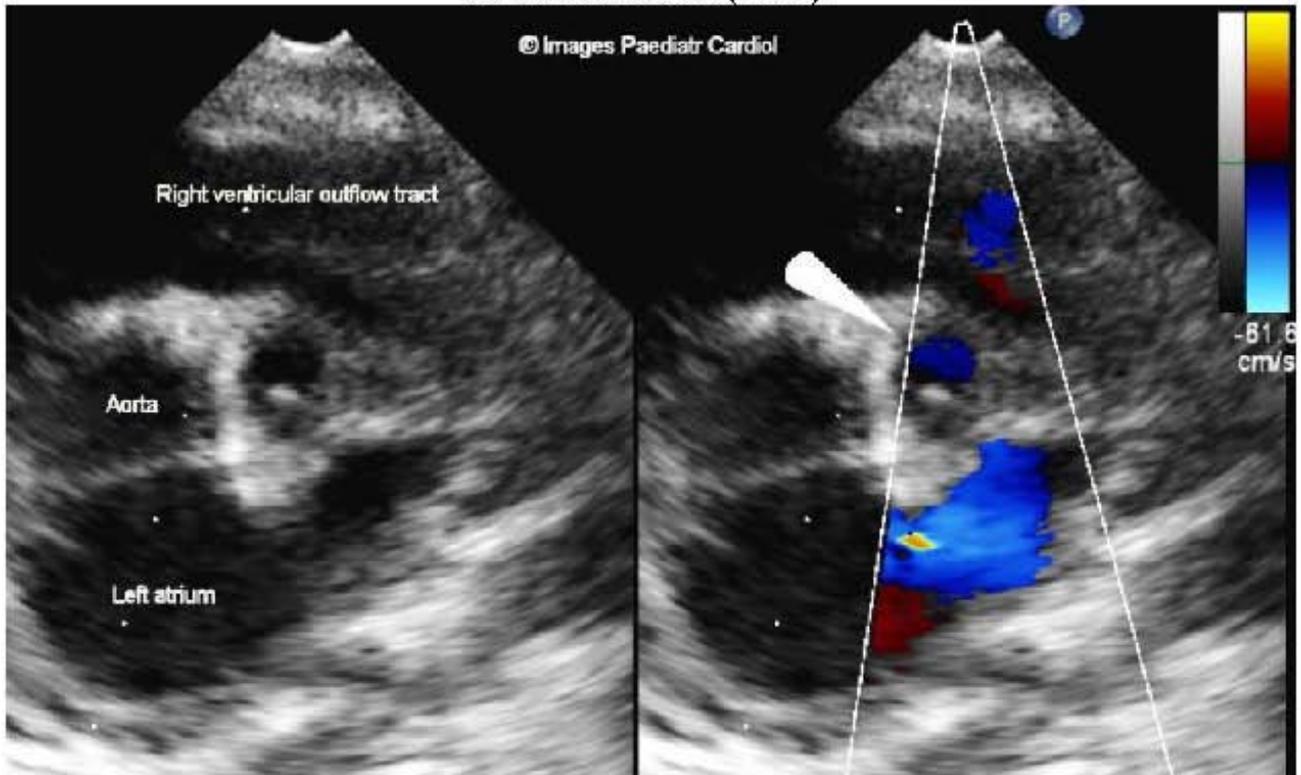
As figure 2 showing a left coronary artery aneurysm, with arterial Doppler flow and with a clot (arrow).
